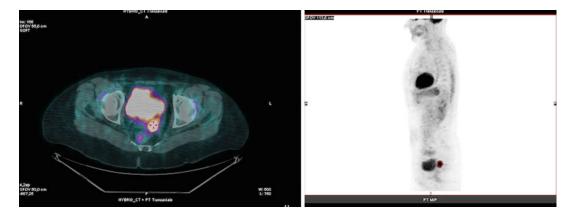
Local recurrence of endometrial cancer in a 72-year-old female patient previously treated with surgery is demonstrated on a ¹⁸FDG PET/CT study (markers)
